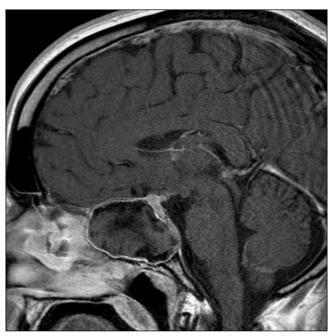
MRI Brain, T1 with contrast, sagittal view demonstrates large mass in the sphenoid sinus and a normal appearing pituitary gland posterior to the mass.
